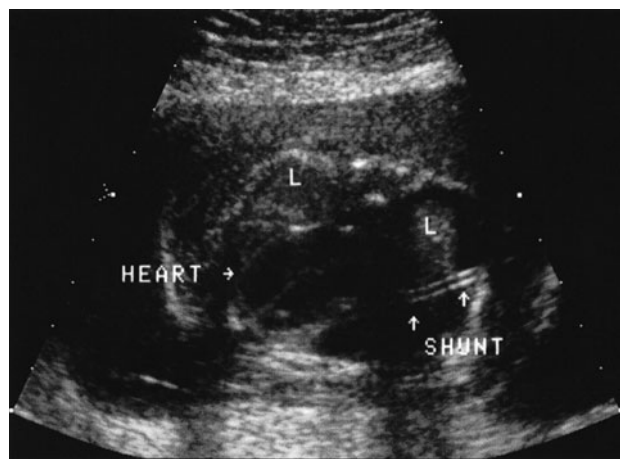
Ultrasound image of large congenital cystic adenomatoid malformation following the placement of a thoracoamniotic shunt. L, lung.
